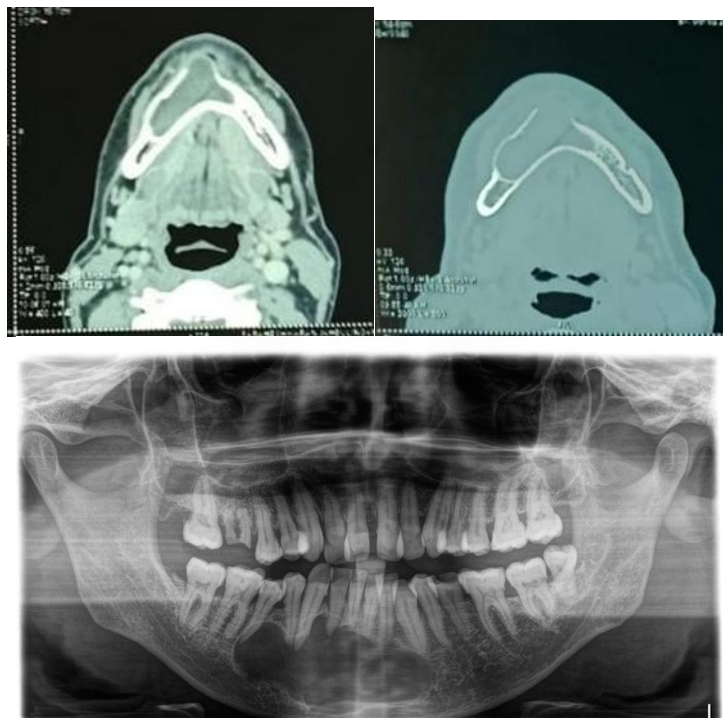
Radiographs Showing Well Defined Radiolucency With Corticated Border Involving The Buccal And Lingual Cortex.
